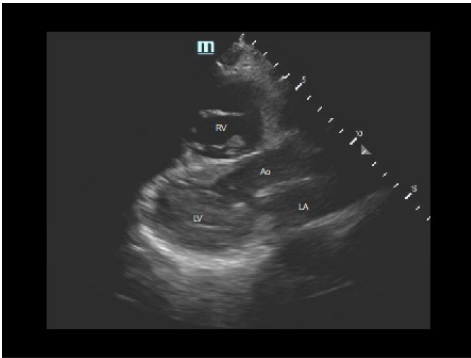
Dilated right ventricle viewed on parasternal long axis view. The RV is grossly larger in size than the ascending aorta or left atrium.
